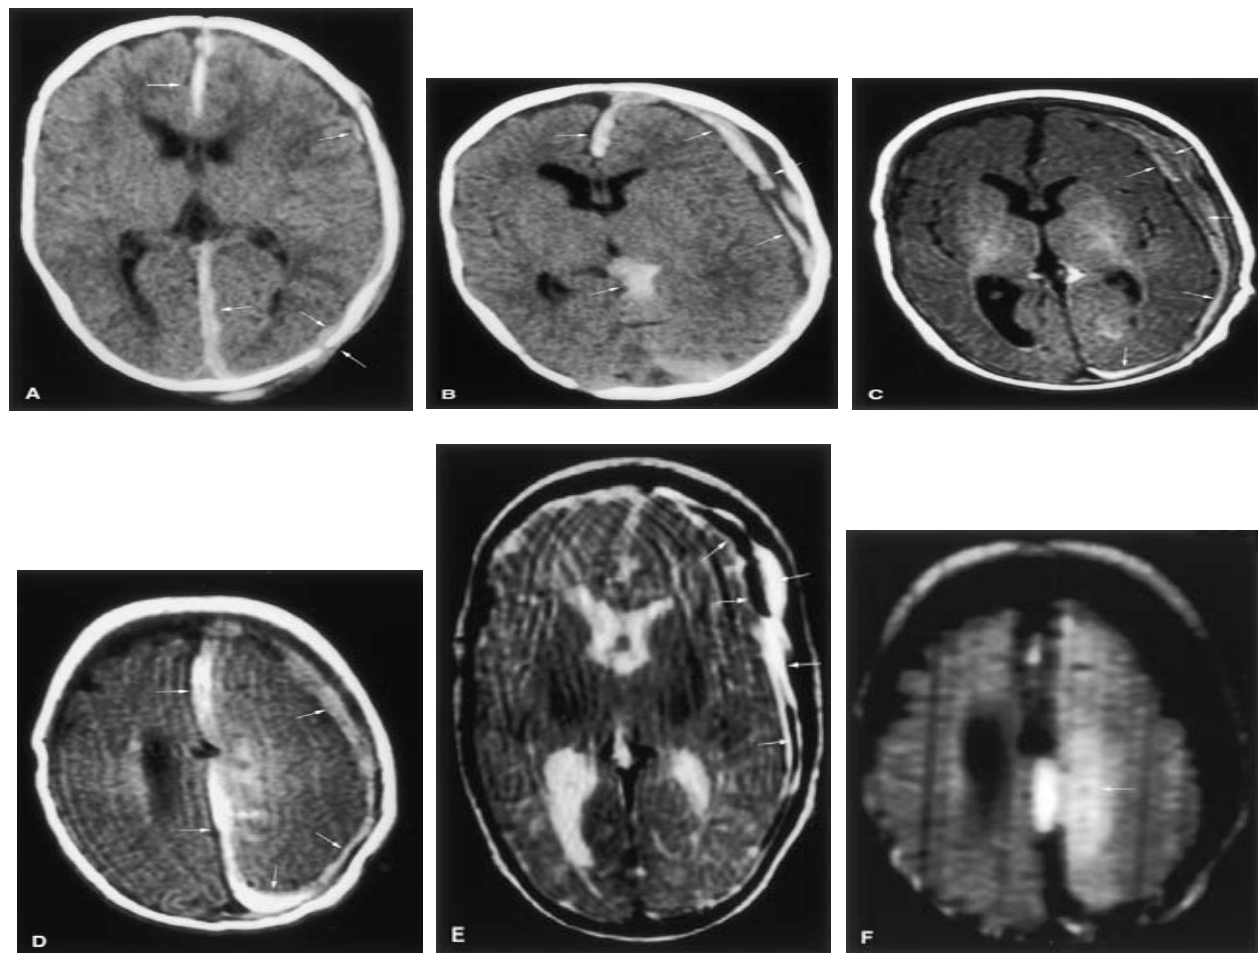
Probable hyperacute-acute subdural hematoma (SDH), evolving chronic SDH, and chronic SDH with rehemorrhage in a 3-month-old boy. The child presented with seizures, lethargy, and retinal hemorrhages. A: Unenhanced axial computed tomography (CT) at initial presentation shows a large interhemispheric high-density hemorrhage (arrows), smaller left convexity extracerebral high-density hemorrhages (single crossed arrows) within low-density extracerebral collections, and a diastatic left parietal fracture (double crossed arrows) with overlying scalp swelling and hemorrhage. Magnetic resonance imaging (MRI) was not done at that time to assist with timing assessment. Following recovery from the acute injury, the infant was placed in protective custody for supervised visits by the parents. Seventeen days later, the child was readmitted to the hospital for acute seizures and neurologic deterioration. B: Unenhanced axial CT at that time shows a large high- and low-density left extracerebral collection (arrows) with swelling of the underlying left cerebral hemisphere and rightward shift of the midline markers. High-density hemorrhage also is seen in the interhemispheric fissure (single crossed arrow) and in the cavum velum interpositum (double crossed arrow). Two days later, axial T1 (C, D) and T2 (E) MRI show that the left extracerebral collection has T1-isointense and T2-hyperintense components (hyperacute unclotted portion; arrows) plus T1-hyperintense and T2-hypointense components (acute-to-early-subacute clotted portion; single crossed arrows). These findings are more consistent with a hyperacute-acute SDH (<3 days old) plus an early subacute SDH (<7 days old) than with an evolving chronic SDH or a chronic SDH with rehemorrhage (Table 1). In the latter, even higher T1 and T2 hyperintensities would be expected in a hemorrhage that is 19 days old. MRI findings with regard to the interhemispheric and left posterior parietooccipital convexity collections are most consistent with a combination of chronic subdural hemorrhage and more recent rehemorrhage (double crossed arrows). Extensive hematologic workup ruled out a coagulopathy. F: Axial diffusion trace MRI shows a high-intensity ischemic left parasagittal cerebral infarction (arrow) likely related to subfalcine herniation.
